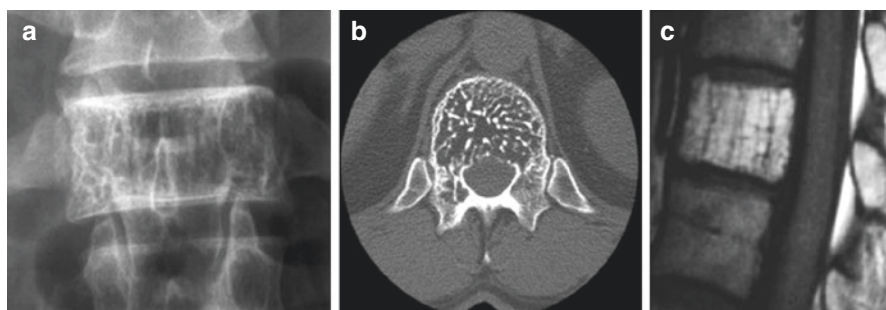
(a–c) Thickening of bone trabeculae in a classic, nonaggressive haemangioma resulting in a “jail bar” or “honey-combing” appearance on plain radiography (a) and corresponding “polka-dot” sign on axial CT images (b). Sagittal T1-WI image (c) also showing the “jail bar” appearance, as well as a high signal intensity due to the fatty component of the lesion
